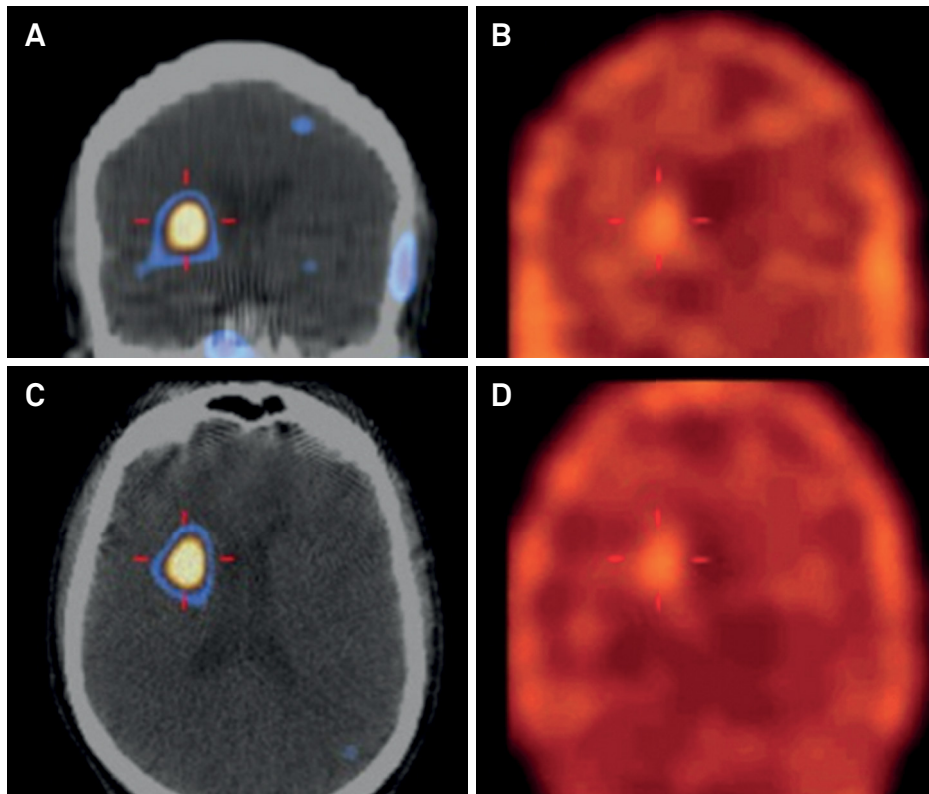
Scintigraphic imaging with single photon emission computed tomography shows normal ^{99m}Tc -TRODAT uptake in the right striatum, and absence of the radionuclide concentration on the left side.
